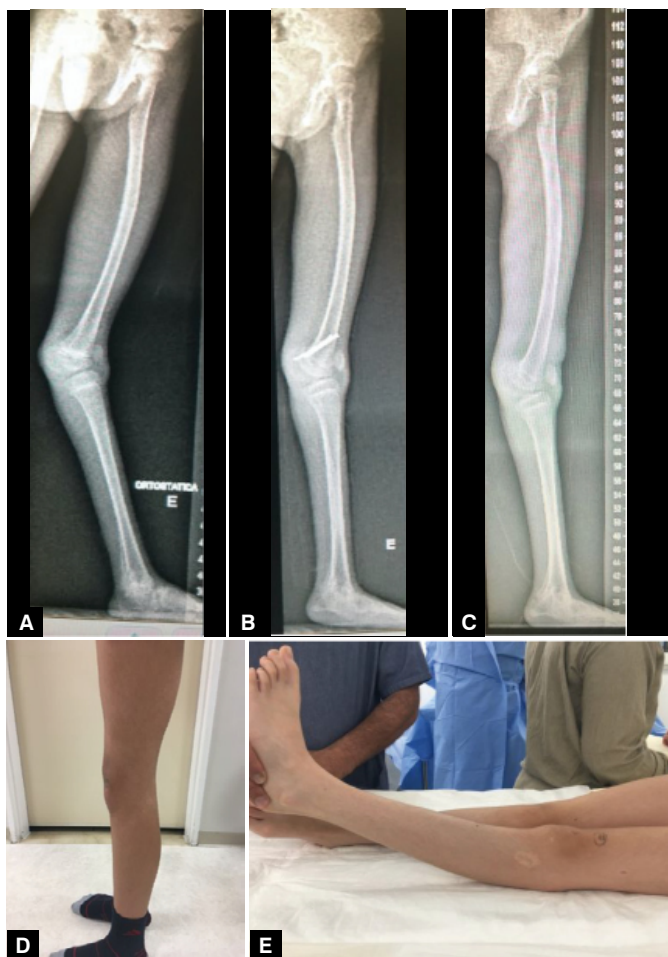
(A) Panoramic radiograph of the left lower limb in profile, a 9-year-old female patient, demonstrating a 32-degree knee recurvatum deformity due to joint hypermobility; (B) Panoramic radiograph of the left lower limb in profile, 1 year and 1 month after surgical treatment with posterior epiphysiodesis of the distal femur, showing correction of the knee recurvatum deformity; (C) Panoramic radiograph in profile, 1 year and 2 months after the removal of the screws from the posterior epiphysiodesis of the distal femur, with maintenance of the correction of the left knee recurvatum deformity; (D) Preoperative photograph of the left lower limb in profile, demonstrating the left knee recurvatum deformity; (E) Photograph taken 1 year after the correction of the left knee recurvatum deformity by posterior epiphysiodesis of the distal femur.
